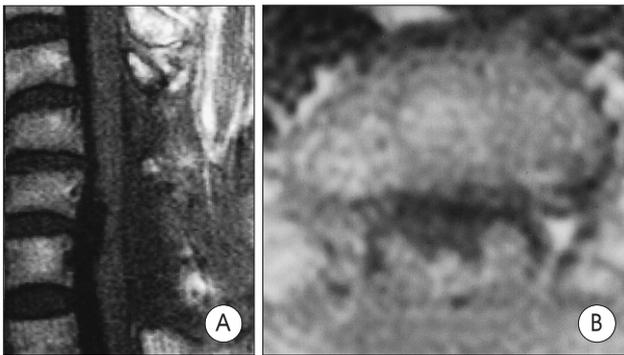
Postoperative spin echo sagittal(A), and axial(B) T1 weighted magnetic resonance image showing disappeared cystic lesion and dorsolateral expansion of the spinal cord. Adjacent cerebrospinal fluid space widening are only seen.
